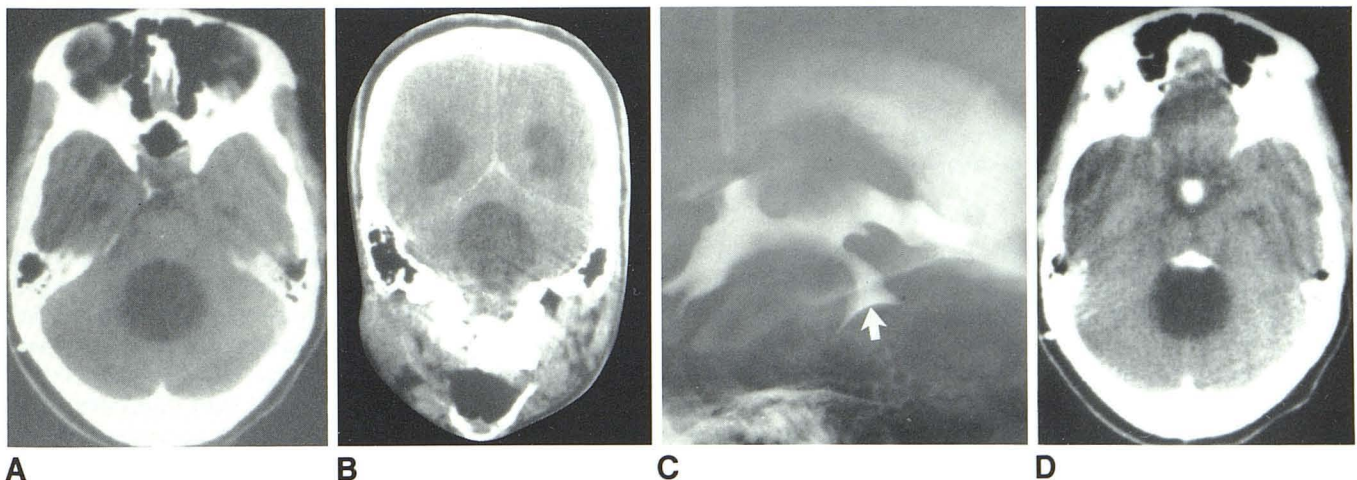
Midline posterior fossa ependymal cyst. Initial transaxial (A) and coronal (B) CT scans. Apparently ballooned fourth ventricle with no filling defects and no abnormal enhancement. C, Lateral supine metrizamide ventriculogram after follow-up CT scan. No interval change in size of presumably
